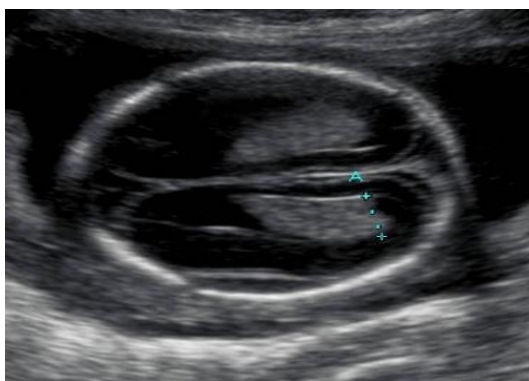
Sonogram of a second trimester normal lateral ventricular diameter. The caliper indicates the boundary of measurement of fetal lateral ventricular diameter
